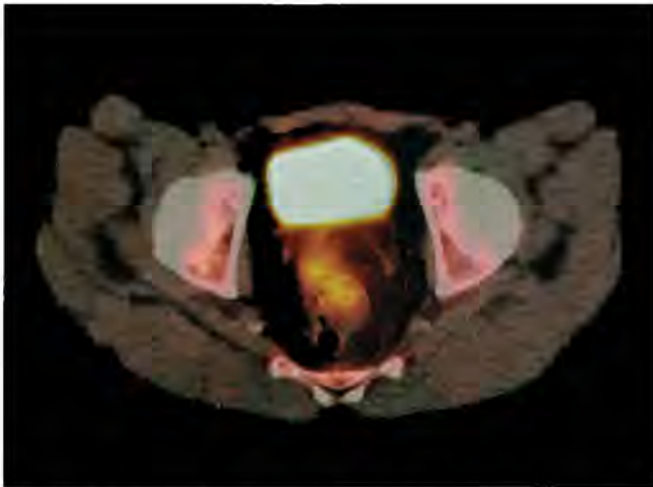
^{18}F -FLT PET/CT: increased uptake in the primary tumor (maximum diameter 60 mm, maximum SUV 10), and in right-sided perirectal lymph node metastasis.
